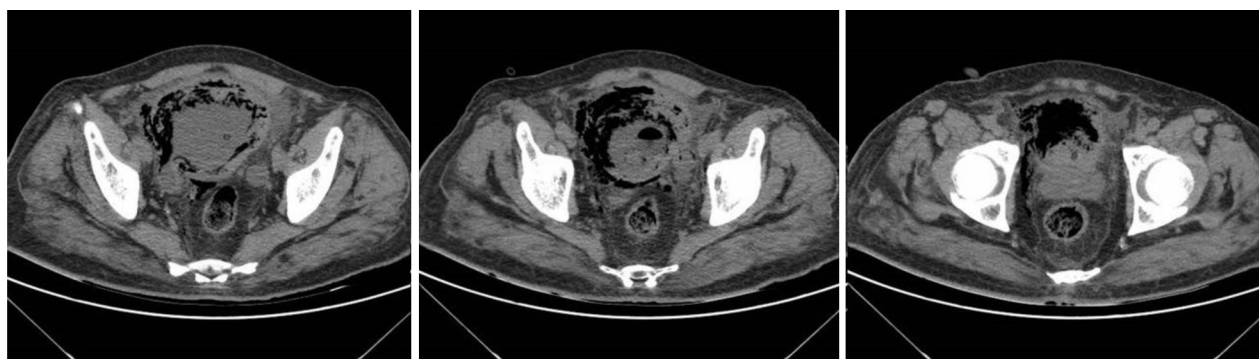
The Computed Tomography (CT) scan of the abdomen and pelvis revealed diffusely increased wall thickness with air bubbles within the bladder wall and disruption of the bladder wall with air bubbles within the para-vesicle spaces.
